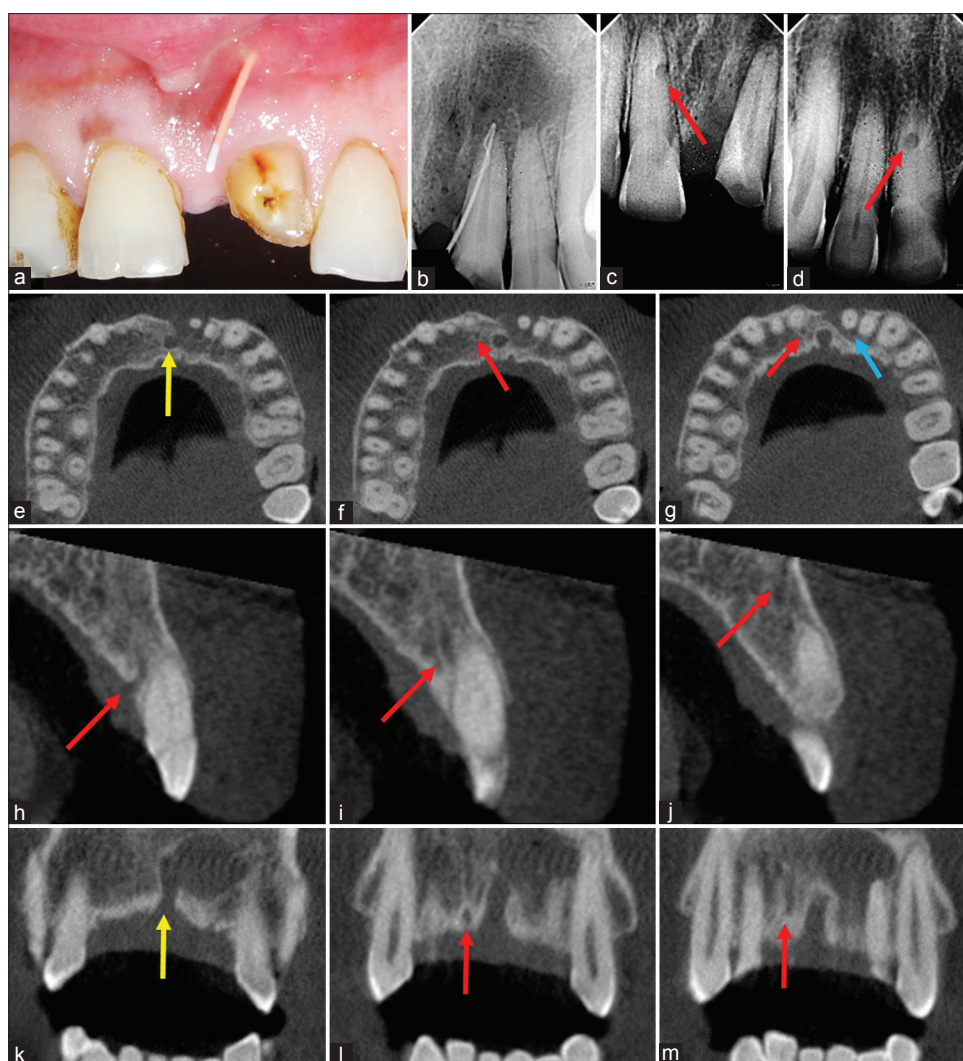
(a) Clinical assessment of sinus tract with relation to tooth 21, (b) radiographic image of sinus tract tracing, (c) radiographic image taken with a straight horizontal angulation suggestive of a resorptive defect with relation to tooth 11 (red arrow), (d) radiographic image taken with a distal horizontal angulation suggestive of an external resorptive defect, present on the palatal side of tooth 11 (red arrow), (e-g) axial sections showing the presence of nasopalatine canal (yellow arrow), accessory canal in relation to tooth 11 (red arrows) and tooth 21 (blue arrow), (h-j) sagittal sections of the anterior maxilla showing the presence of accessory canal with relation to tooth 11 (red arrows), (k-m) coronal sections of the anterior maxillary region showing the presence of nasopalatine canal (yellow arrow) and accessory canal in relation to tooth 11 (red arrows)
